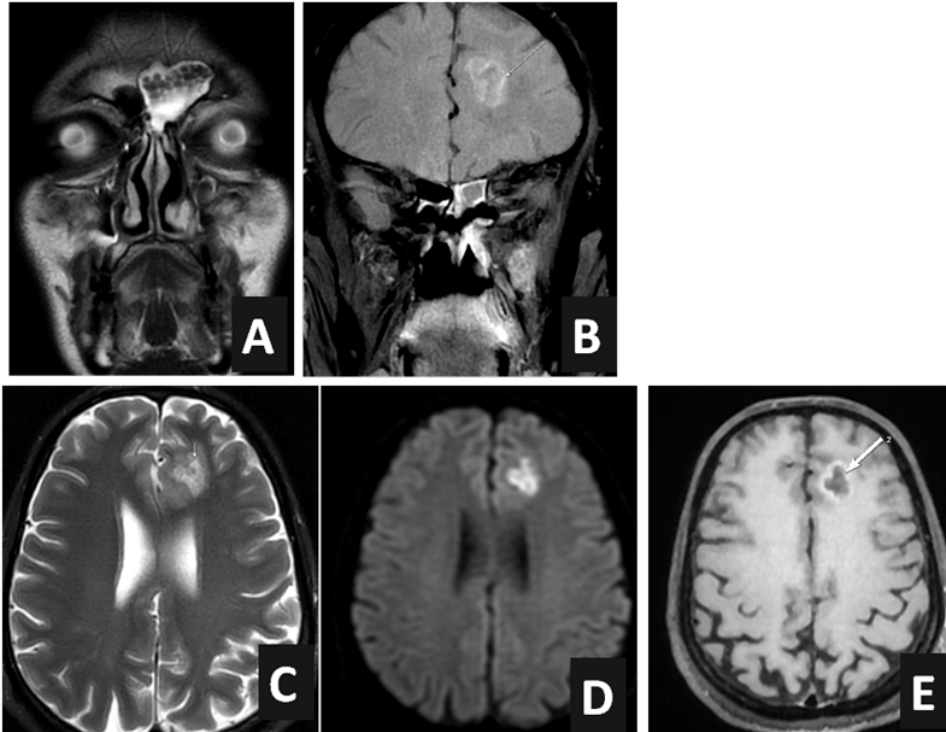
A to E: Intracerebral fungal abscess: Note left frontal sinus inflammation due to fungal disease in coronal T2W image (A); FLAIR coronal images show high signal area at left frontal lobe (B). Axial T2W image (C) show high signal heterogenous lesion at left medial frontal region at the same level as B. DWI images show diffusion restriction (D). Post contrast scans show mild rim enhancement (E- arrow).
